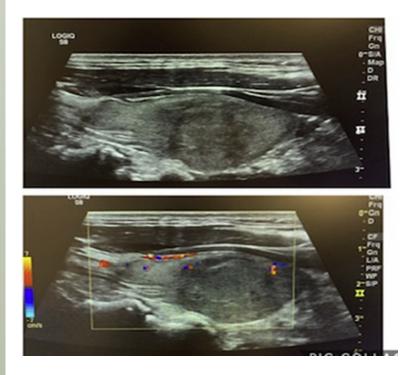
A 62-year-old man presented with thyrotoxicosis from Graves' disease. Thyroid ultrasound showed a left thyroid lobe solid nodule 2.3×1.9 cm (ACR TI-RADS 4). A nuclear uptake scan reported this nodule to be cold, and biopsy proved to be medullary thyroid cancer.
